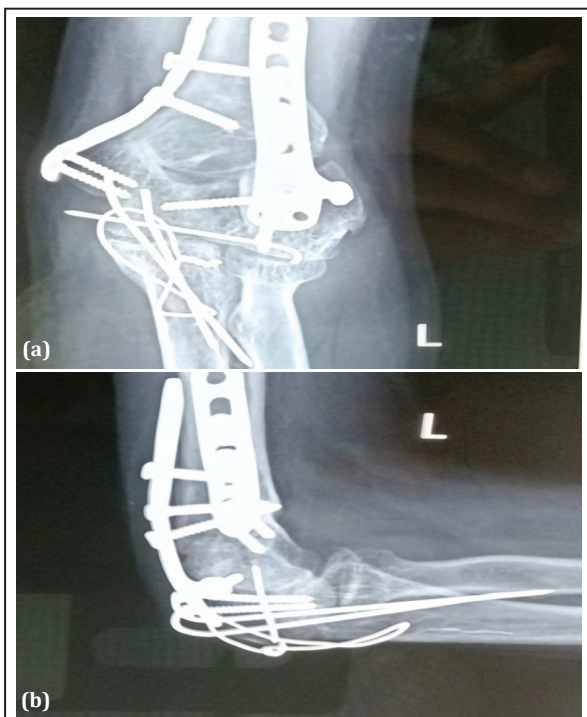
Radiographs of left elbow antero-posterior and lateral views at 6 months follow-up.
